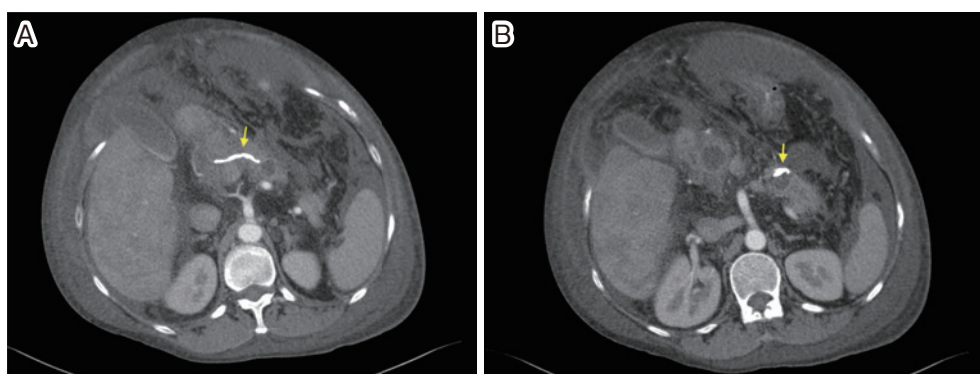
Contrast-enhanced computed tomography shows the persistence of the NBCA cast at the intrapancreatic duct (A) and intra-pseudocyst (B) after transcatheter arterial embolization.
